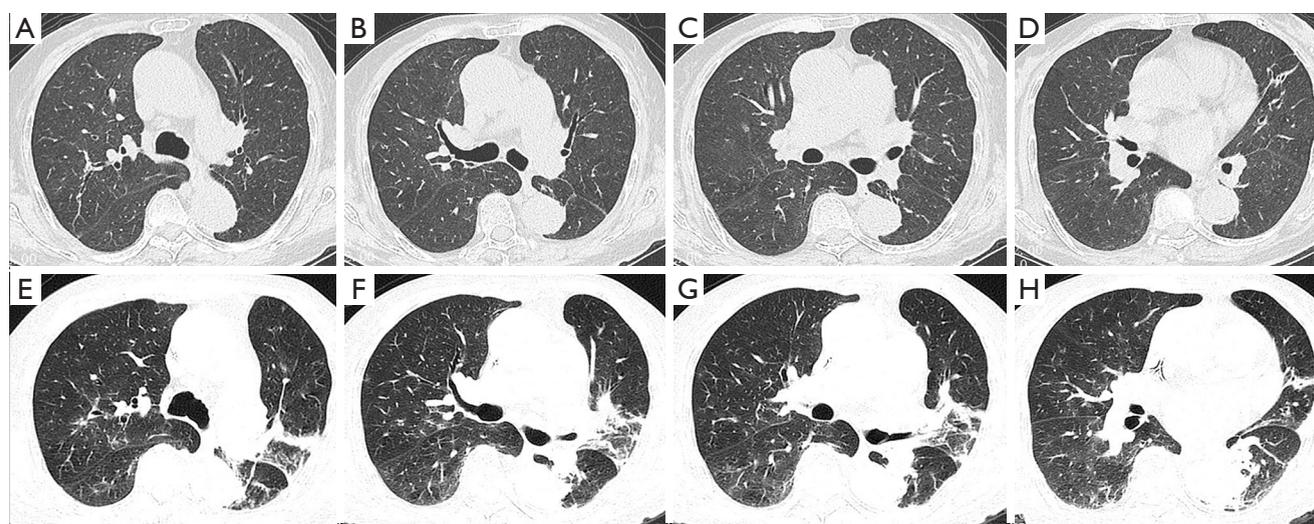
CT of the lung for the patient. (A-D) CT after toripalimab and rituximab treatment in March 2023. (E-H) CT of progressive disease in June 2023. CT, computed tomography.
